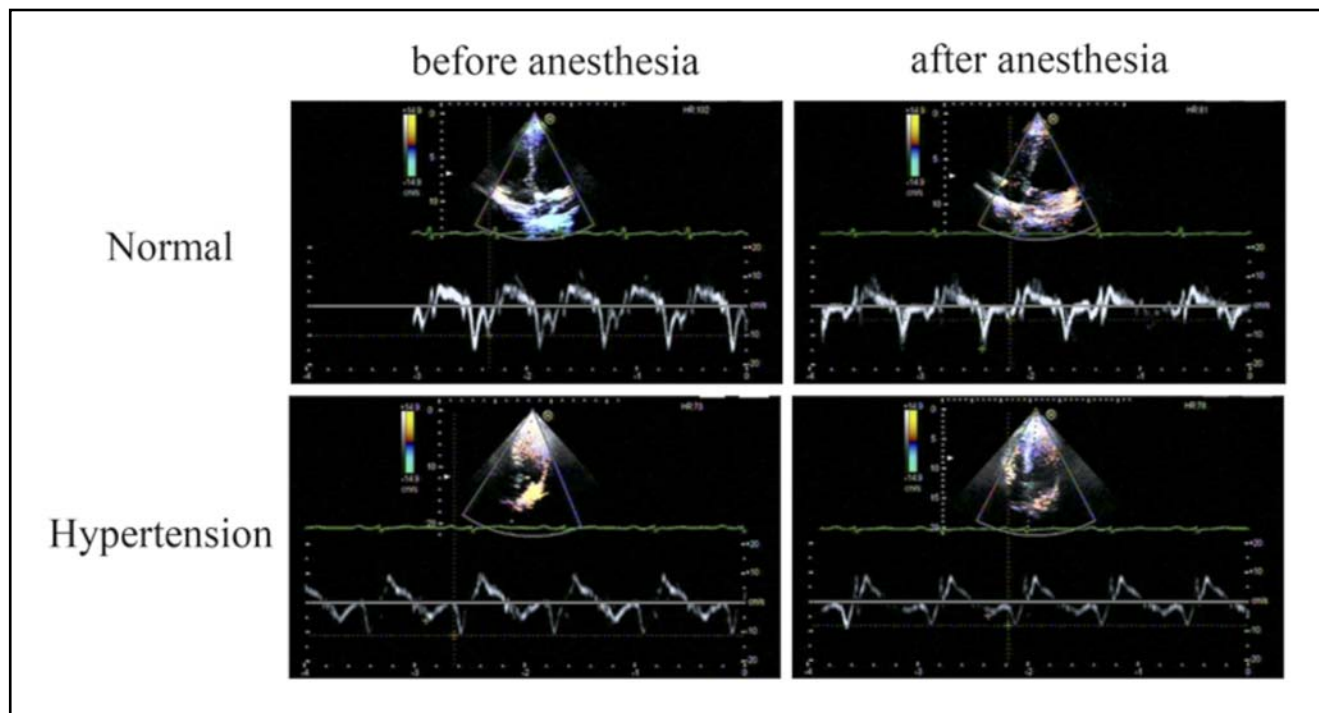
Mitral annulus tissue Doppler before and after General anesthesia in two groups. In hypertension group, E/A is lower than 1 (E/A <1). In both group, Aa peak all decreased after General anesthesia. While Ea peak reduced after General anesthesia in hypertension group.
